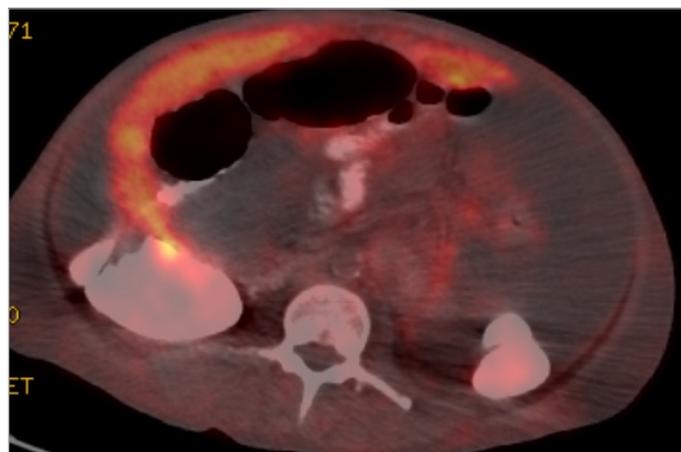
PET CT. Increased peritoneal FDG involvement.
